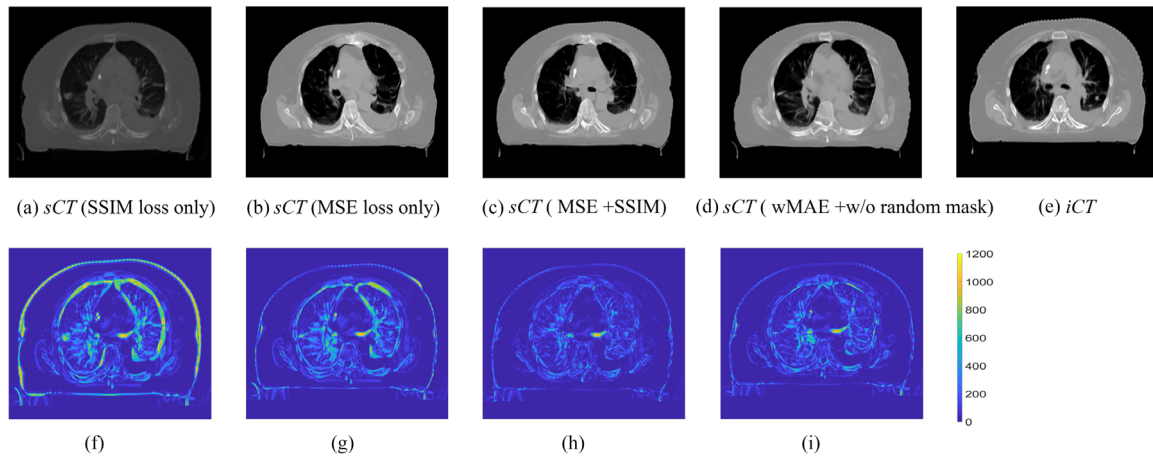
Sample slices of the *sCT*s generated by the models trained with different loss terms and the corresponding *iCT* (e). Figure (a) and (b) are the sample slices of the *sCT*s generated by the models trained with the SSIM or MSE loss term only, respectively. Figure (c) shows the sample slice of the *sCT* generated by the model trained with both the MSE and SSIM loss terms. Figure (d) shows the sample slice of the *sCT* generated by the model trained with the wMAE loss term without random mask strategy. The CT HU number display window position and width were -120 and 1300 HU, respectively. Figure (f)-(i) show the corresponding absolute differences between the *sCT*s and *iCT*.
